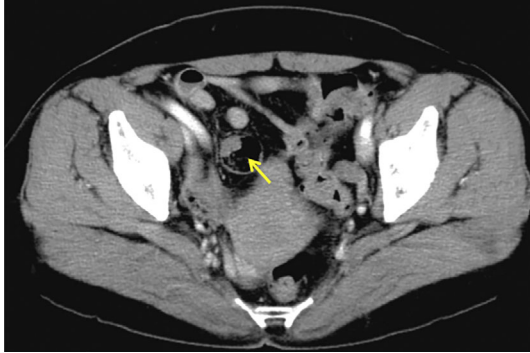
Contrast enhanced computed tomography performed during the portal phase reveals a non-enhancing, hemispheric elevation within the ileum (yellow arrow).
